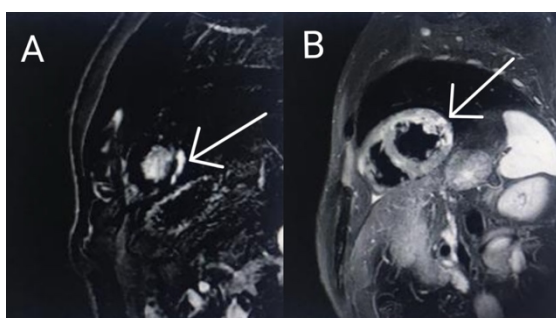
Cardiac magnetic resonance imaging. A: subepicardial lateral apical delayed gadolinium enhancement in favor of myocarditis. B: dark-blood T2-weighted imaging showing hyperintense signal of the lateral wall in favor of myocardial edema
